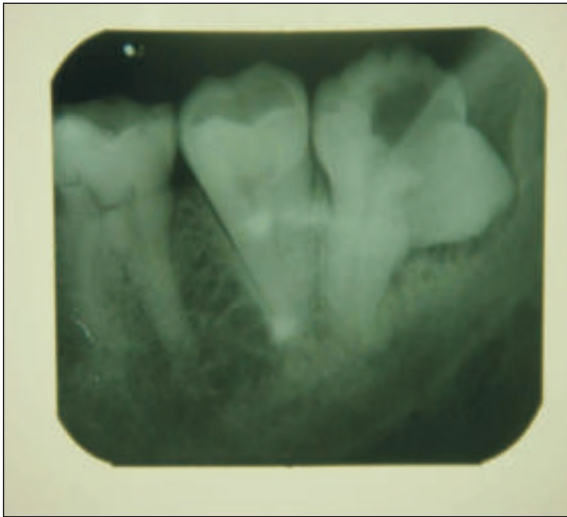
Intra oral periapical radiograph showing the distance of the tooth from the inferior alveolar canal.
